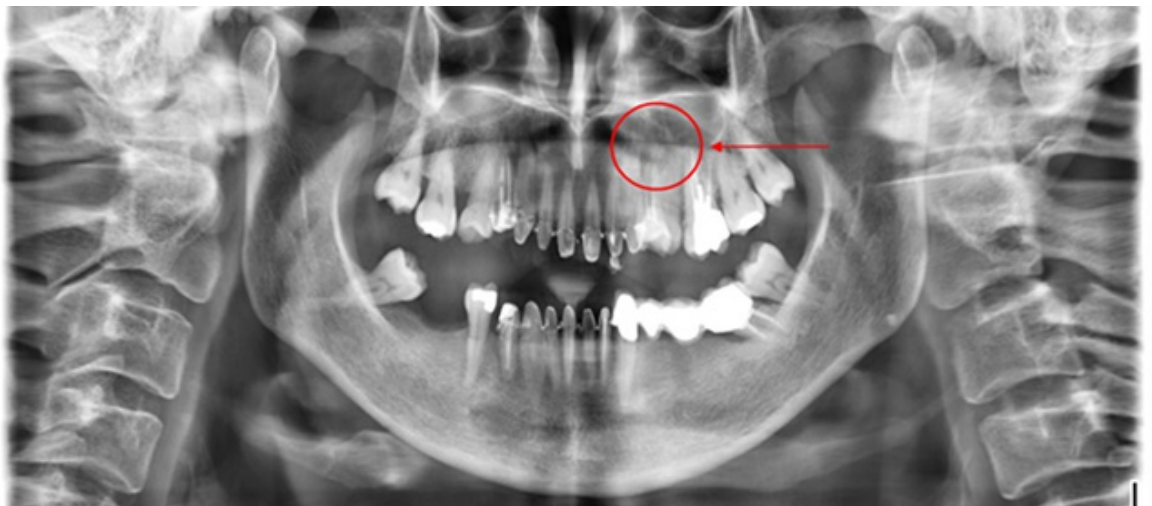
Orthopantomography performed on the patient after the dental session. The red circle shows where the periapical lesion is located.
